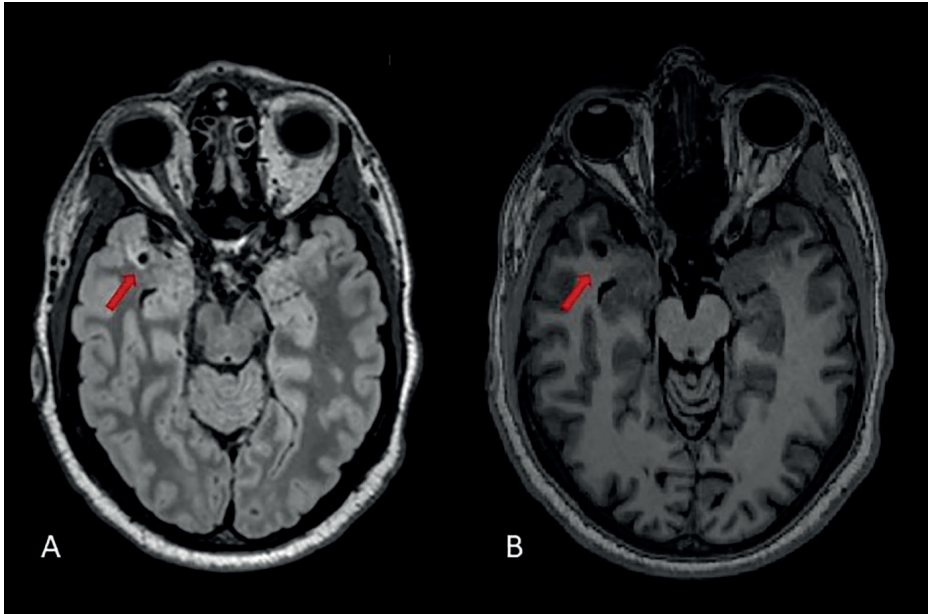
Lacune visible in the temporal lobe in one patient with hypertension, shown on FLAIR (A) and T1 (B).
